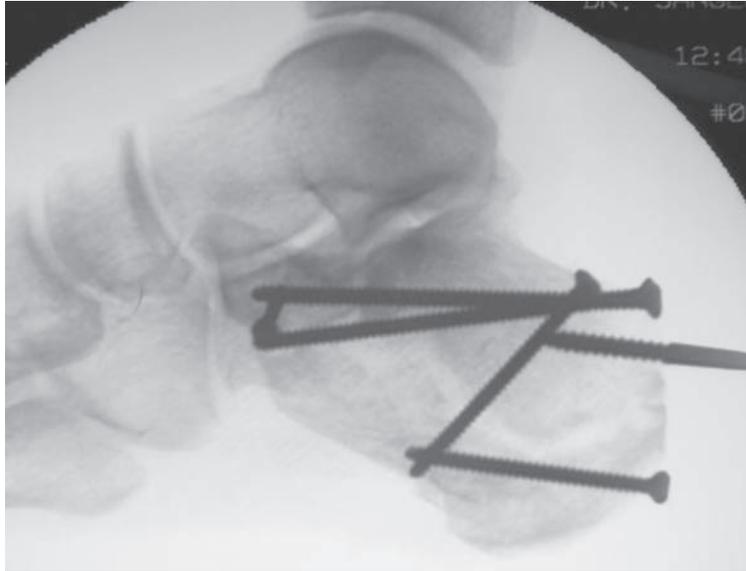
In this lateral radiograph, the facets have been reduced and the height restored. Small fragment screws maintain rigid fixation. The Shanz pin is removed after reduction. The patients begin active range of motion on post operative day one.
